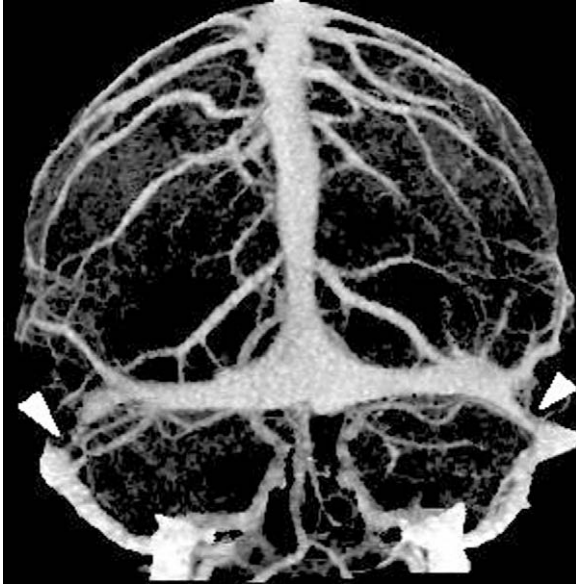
A middle-aged woman was referred with an asymmetric hearing loss, balance disturbance, headache, and right-sided PT. Volume-rendered image from a CT venogram study demonstrates bilateral severe stenoses of the transverse sinuses (arrowheads), typical of that seen in idiopathic intracranial hypertension.
